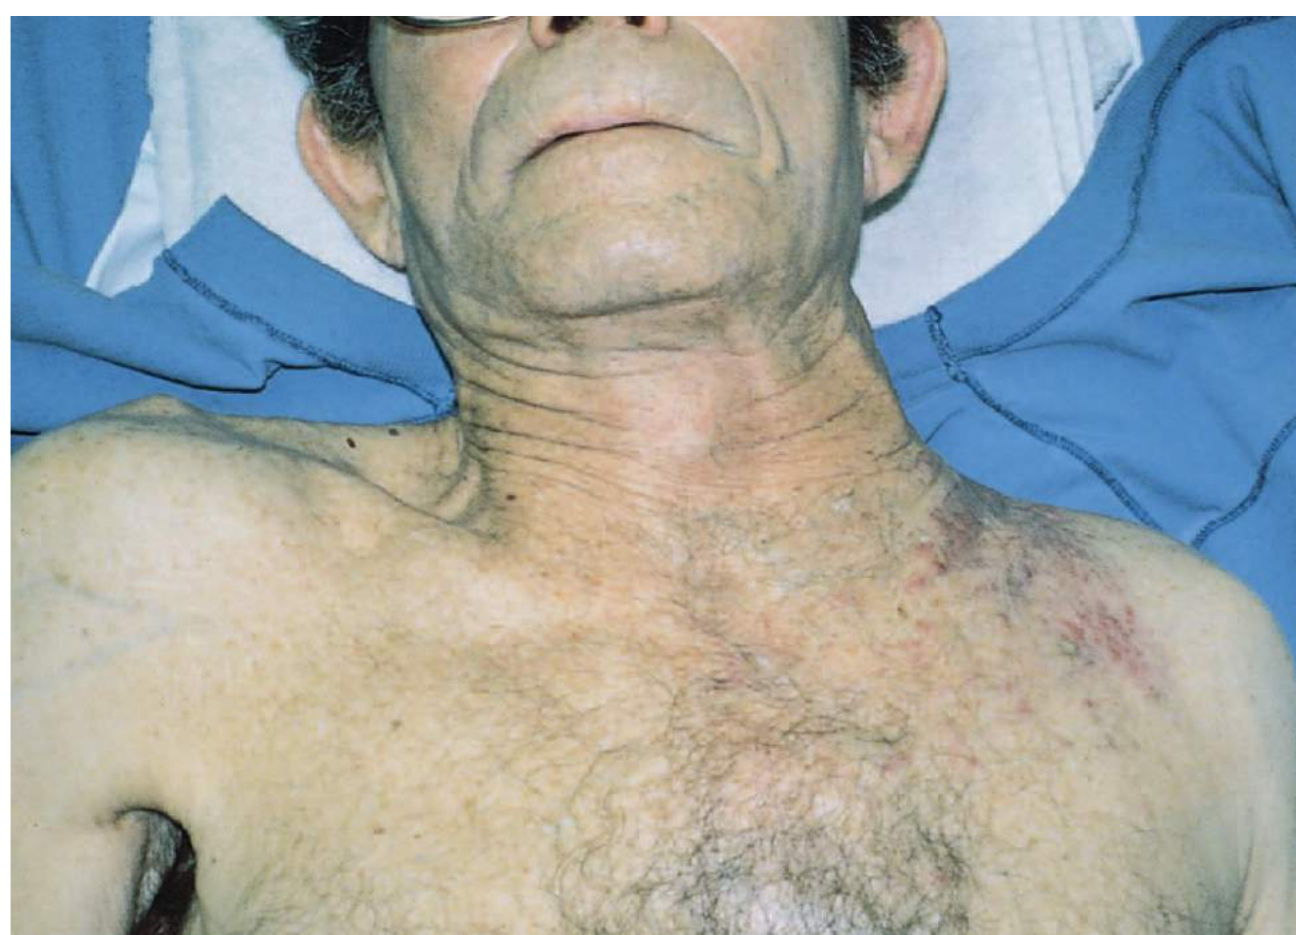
■ Apical Lung Mass. This 68-year-old man cigarette smoker complained of cough and weight loss. A chest radiograph shows a left apical tumor. There is erosion of the tumor into the chest wall, with an indurated supraclavicular and infraclavicular mass. Moderate JVD is apparent, suggesting venous outflow obstruction. (Photo contributor: Stephen W. Corbett, MD.)
